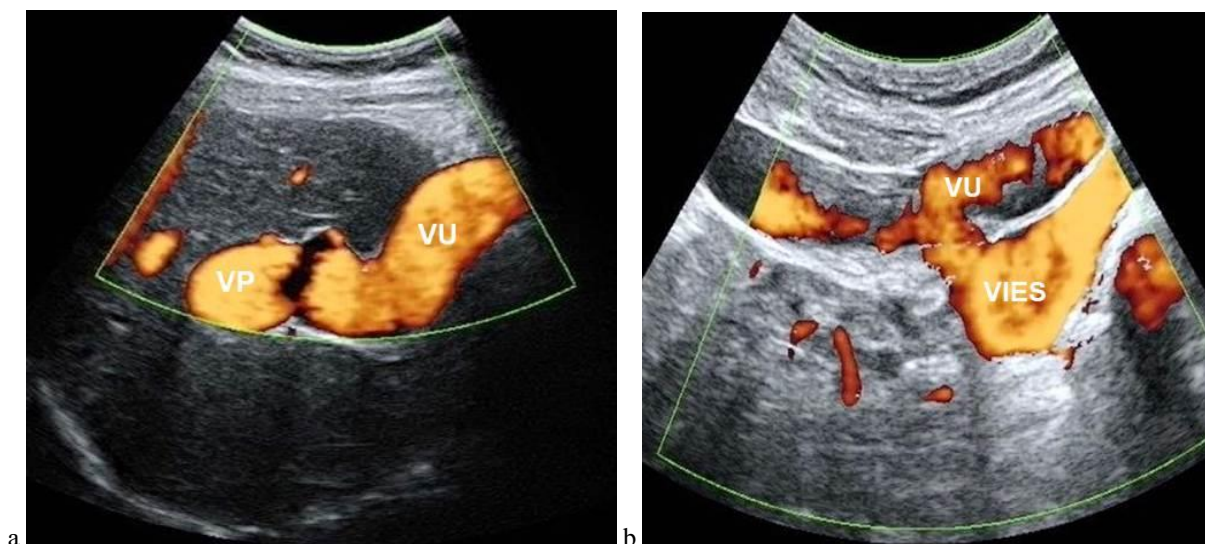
Ultrasound images, power doppler mapping
